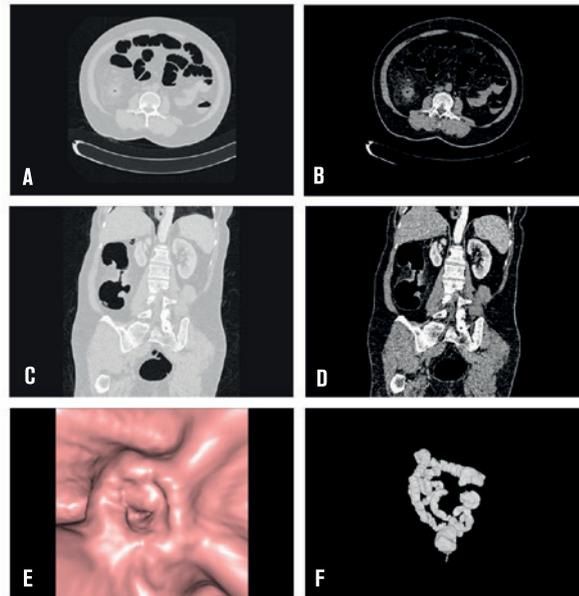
A 54-year-old female patient with pain and anemia underwent incomplete colonoscopy; Axial-coronal MPR images (A-D) show asymmetric tumoral wall thickening at proximal ascending colon leading to remarkable lumen narrowing. Neighboring signal increments and lymph nodes in axial MPR images (B). 3D endoluminal image (E) shows the tumor. Appearance of an eaten apple in CT colonography (F). The pathology report revealed moderately differentiated adenocarcinoma.
